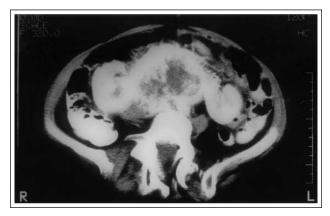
Retroperitoneal mass seen on CT scan in case two.
